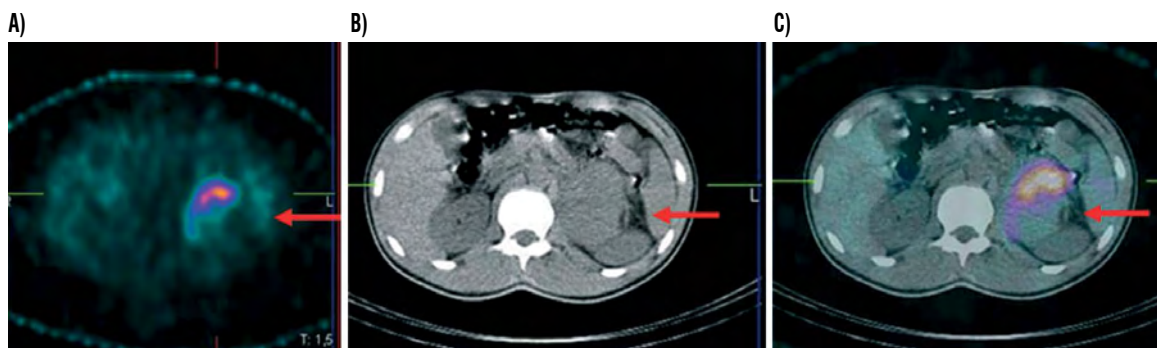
^{123}I -MIBG in Pheochromocytoma. (A) SPECT, (B) CT, (C) Fusion image. Not all tumour seen on CT is active on MIBG study
